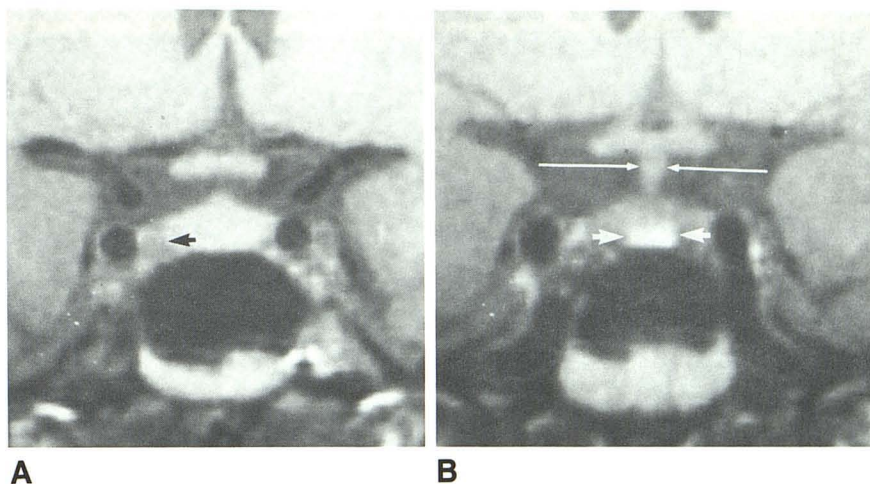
A and B, 29-year-old woman with Cushing disease. T1-weighted coronal images, 600/20, show right-sided 9-mm hypointense adenoma (*short arrows*) with slight upward convexity of pituitary gland. B (3 mm posterior to A) also shows slight leftward shift of pituitary stalk (*long arrow*). At surgery, low-intensity focus corresponded to 8-mm right-sided ACTH-secreting adenoma. (Right half = true positive; left half = true negative.)
